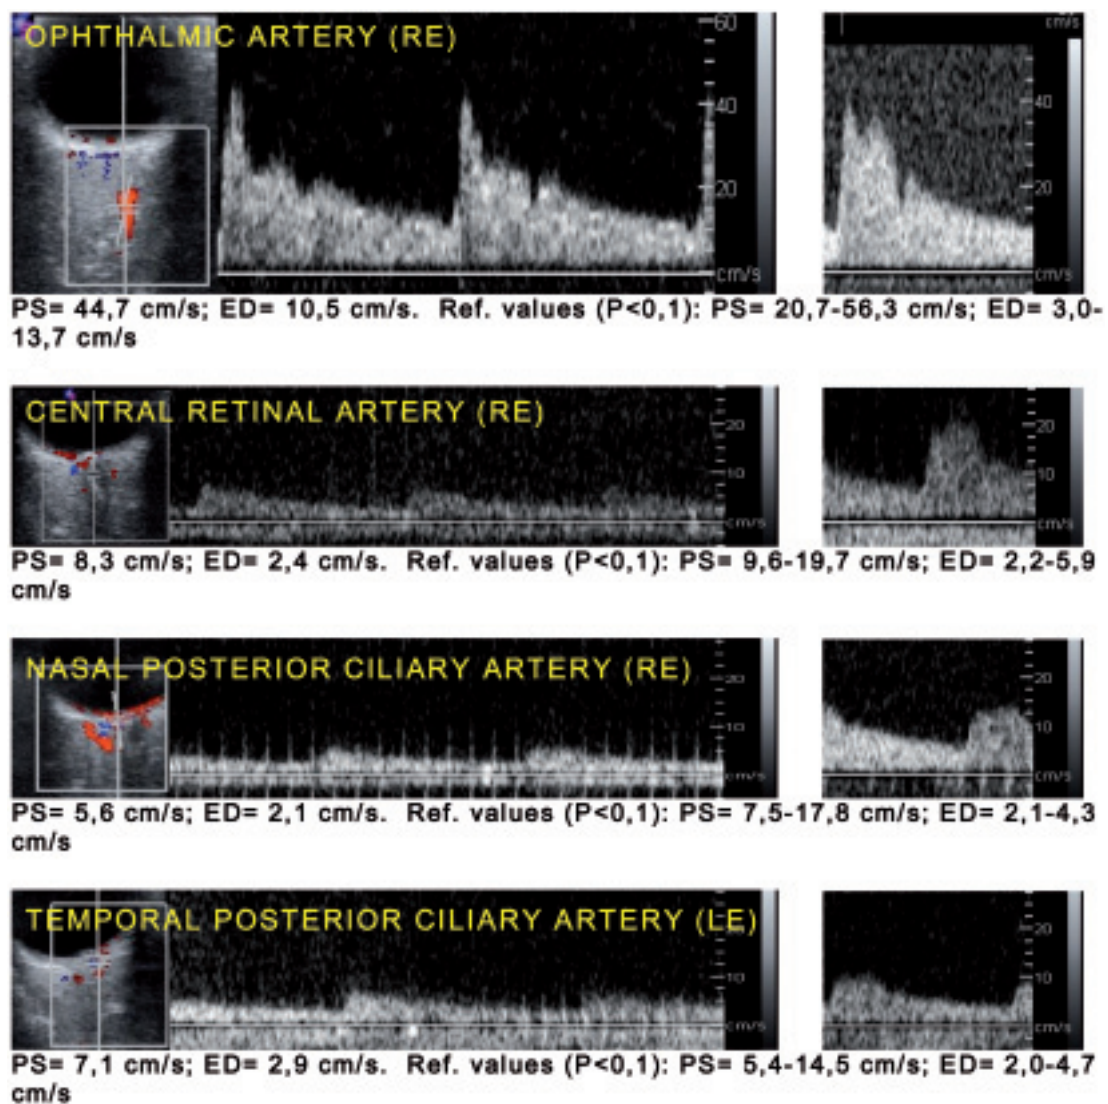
Left - Color Doppler Imaging of our patient: note the values of the peak systolic (PS) and end diastolic (ED) flow in the small retrobulbar vessels at the lower limit and the normal flow in the ophthalmic artery. Right - Color Doppler Imaging of a normal patient, for comparison.
